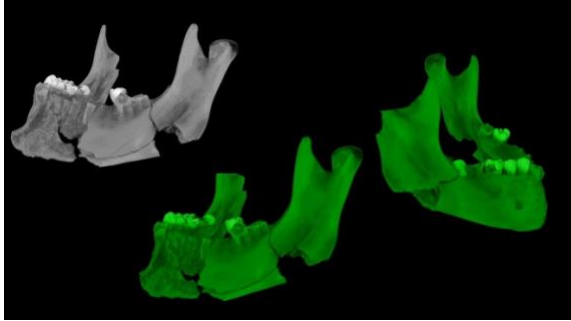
CT imaging of the Case 5 mandible showing the cone crack on the left mandibular body (left and middle) and irregular perforating alteration of the right mandibular body (right)
